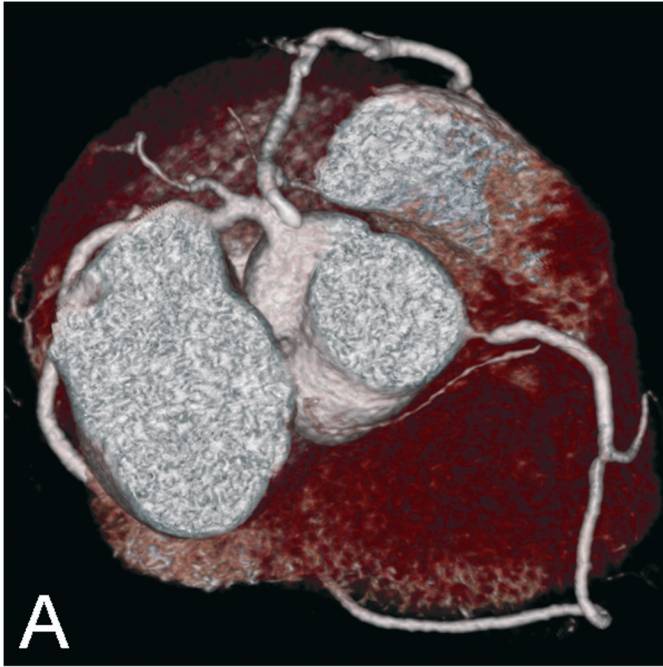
Volume rendered image (A), curved maximum intensity projection (B) and multiplanar reconstruction (C) show a calcified plaque (arrow) located in the LAD just proximal to the origin of a septal branch (S). The size of structures with high X-ray attenuation such as calcifications is overestimated in MSCT due to partial voluming. This calcification superimposes most of the coronary artery lumen. The conventional angiogram (D) shows a normal LAD.
